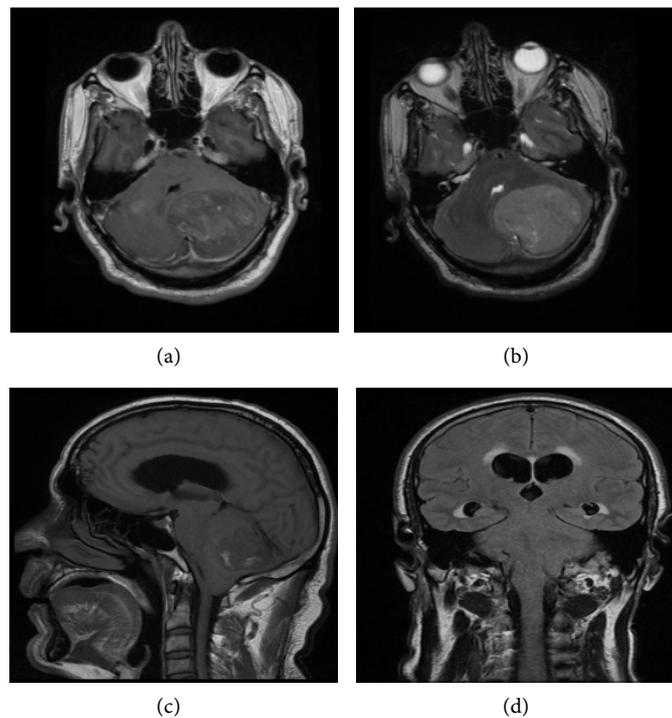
MRI of the brain (a) Axial T1; (b) Axial T1; (c) Sagittal T1; (d) Coronal T1 show a mass in the posterior fossa lying within the cerebellar hemisphere and moderately enhancing along with obstructive hydrocephalus significant mass effect and tonsillar herniation.
